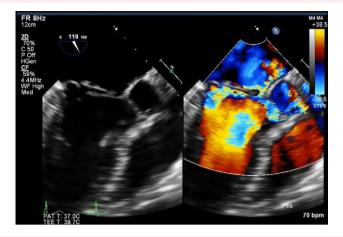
Transoesophageal echocardiography showing severe mitral regurgitation and ruptured chordae tendineae attached to the P2 segment (arrows) and a vegetation (up to 16 mm, arrowheads). Ao, aorta; LA, left atrium; LV, left ventricle.
